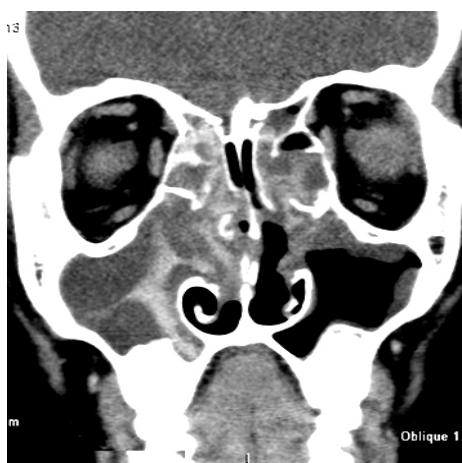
postoperative coronal CT showing recurrent AFS without orbital manifestation
